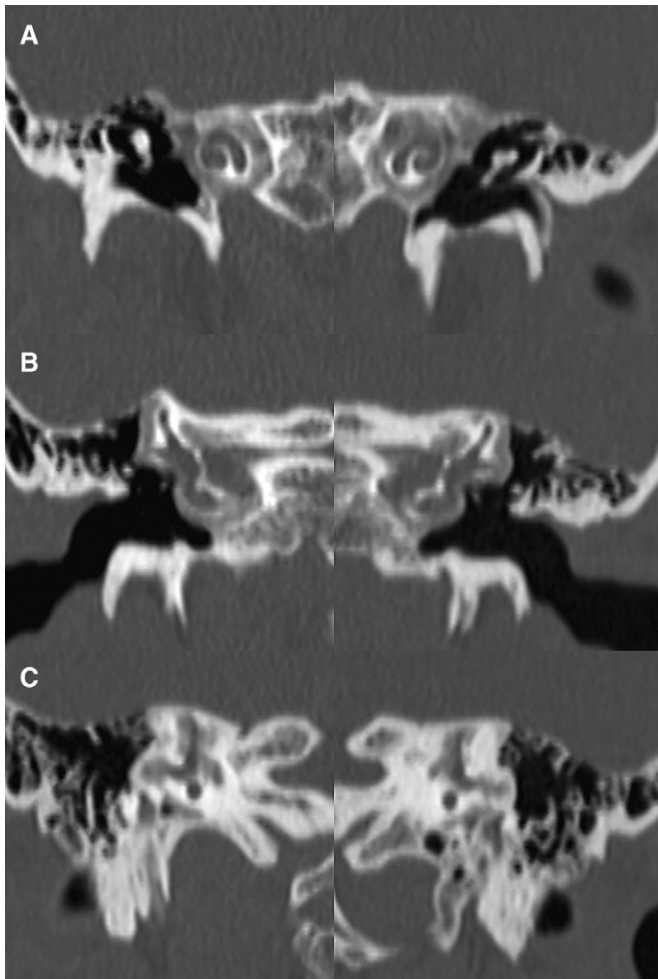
Coronal computed tomography re-formations of the temporal bones at the level of the cochlea (A), vestibule and oval window (B), and semicircular canals (C). There is extensive bony lucency in the otic capsule that surrounds the cochlea, vestibule, and semicircular canals.
